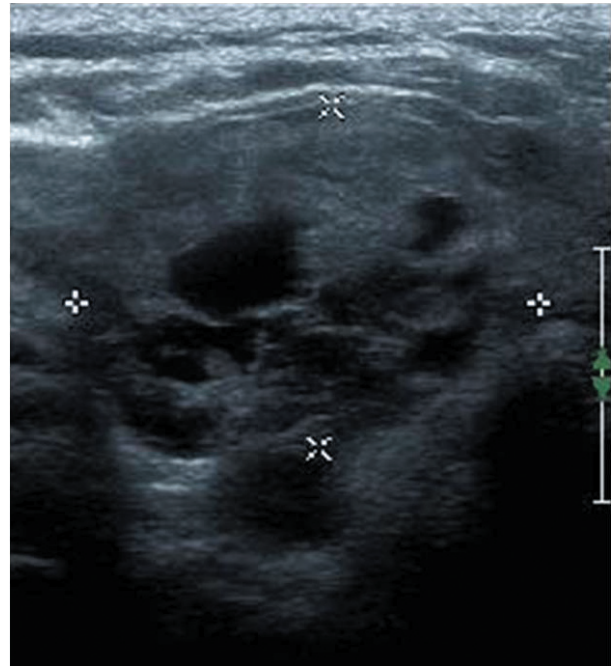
Ultrasonography image. The mass 3.5cm in size is found in the right lobe of thyroid gland, and cystic degeneration is obvious within it.
